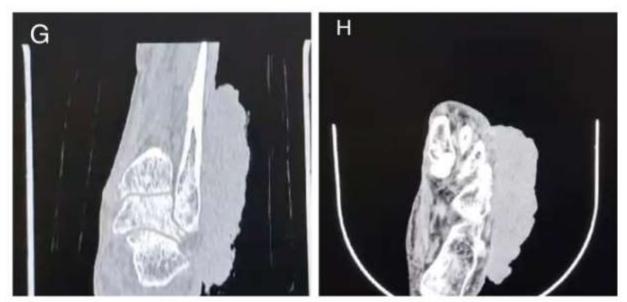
CT LEFT ANKLE WITH FOOT showing heterogenous lobulated soft tissue density mass (Coronal view). Figure H:- CT LEFT Ankle With Foot showing heterogenous soft tissue denity mass (axial view).
